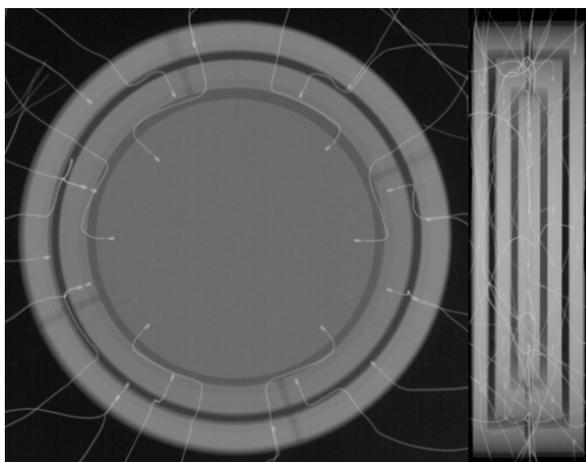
Top and side radiography of the LNE-LNHB graphite calorimeter detector, small white points are thermistors embedded in the graphite core (centre) and in the jacket and the shield surrounding the core.
